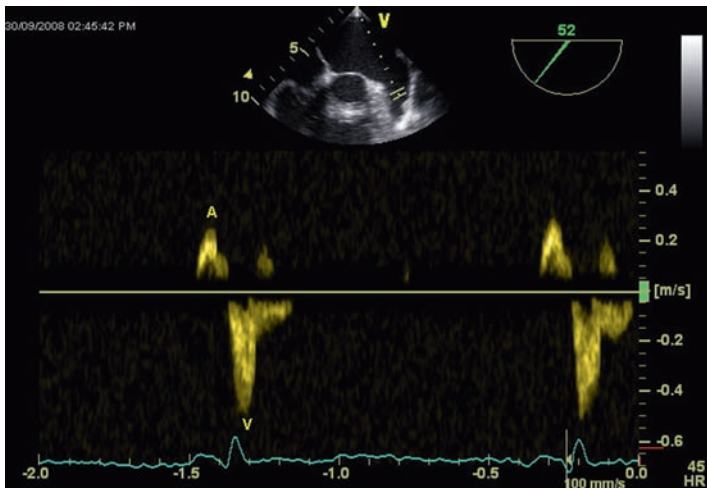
Pulse wave Doppler of left atrial appendage blood flow demonstrating emptying (A) and filling (V) velocities.
